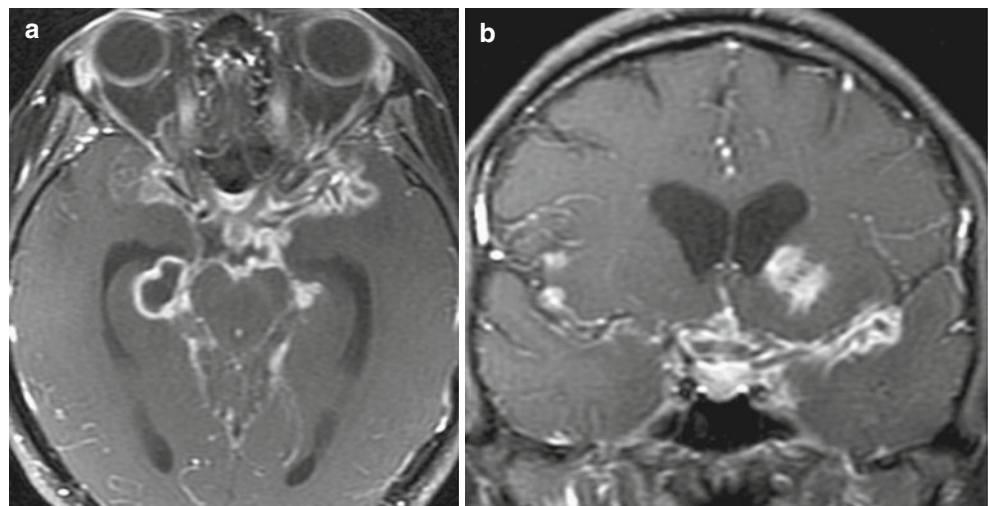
Tuberculous meningitis. (a, b) Axial and coronal Gd-enhanced T1-weighted images show diffuse meningeal enhancement in the suprasellar, sylvian, and peri-mesencephalic cisterns. An enhancing mass is also present in the left basal ganglia
